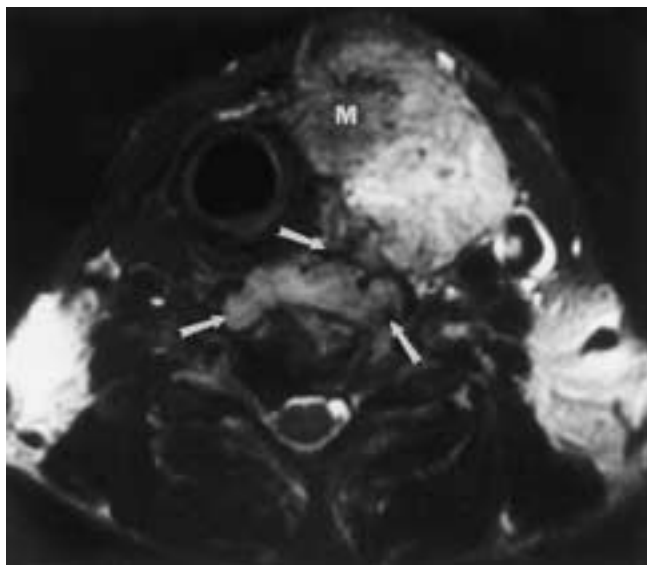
Medullary thyroid carcinoma with direct extension into the vertebral compartment. Axial T2-weighted MR image shows a large, heterogeneous mass (M) in the left lobe of the thyroid gland. There is direct invasion of the longus colli muscle complex and the spine (arrows).
